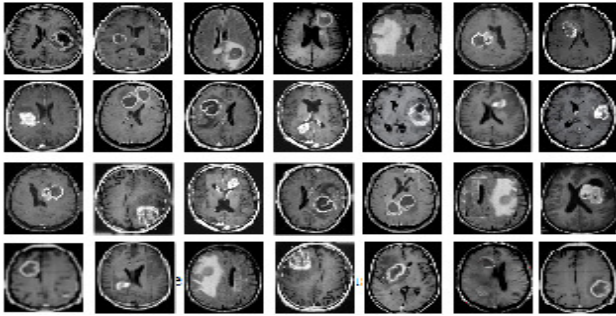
Some samples from the T2-weighted MRI dataset.
